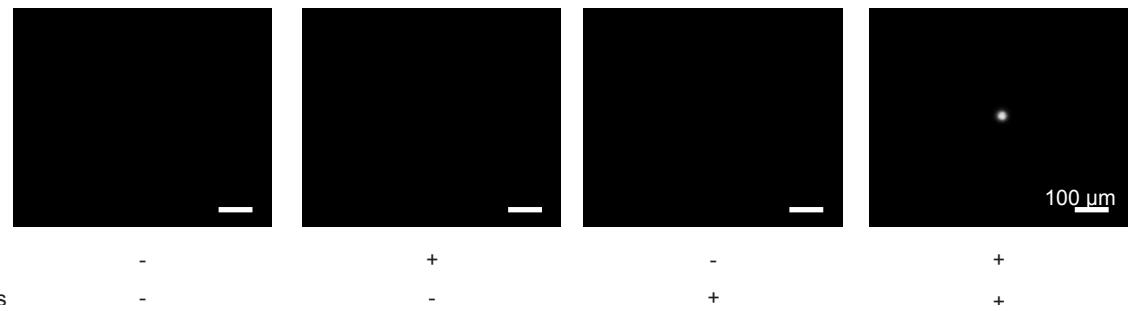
Bacteria cluster formation requires intact intracellular GVs. Fluorescence images of *bARG1*-expressing *E. coli* with intact (+) and collapsed (-) intracellular GVs before and 40 seconds after ultrasound application.
